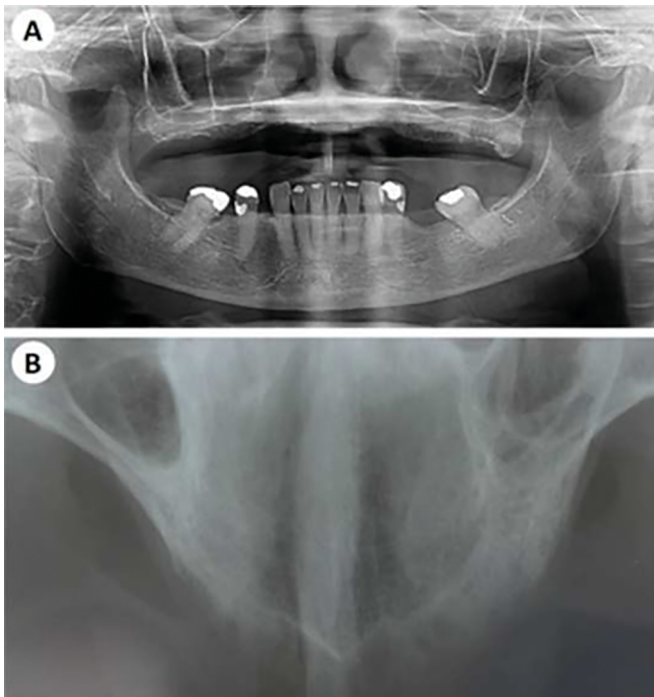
Panoramic and occlusal radiographs with aspect of normality.
